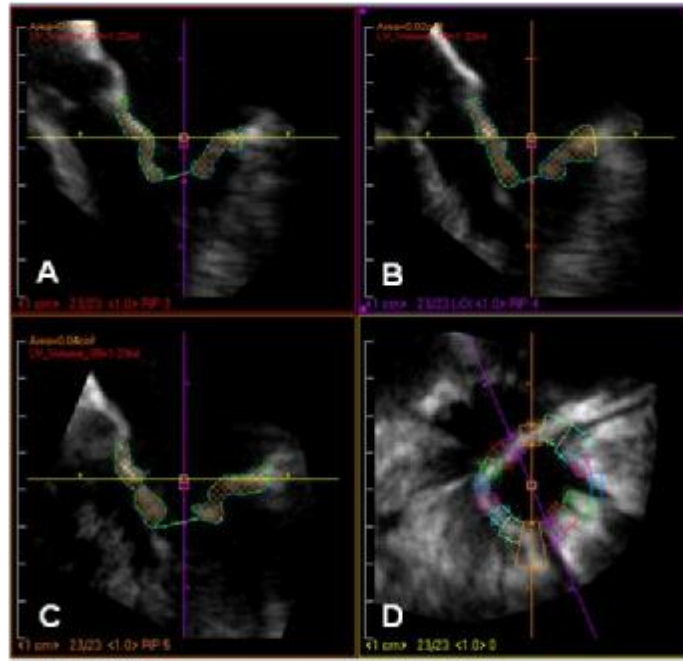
Volume measurement of mitral leaflets by anyplane echocardiography. Three long-axis cut planes constructed around center axis of mitral apparatus (A, B, and C). In these views boundaries of mitral valve subvolumes were traced and their corresponding short-axis views are presented in short-axis cut plane (D). In all, 8 slices were used for volume computation.
